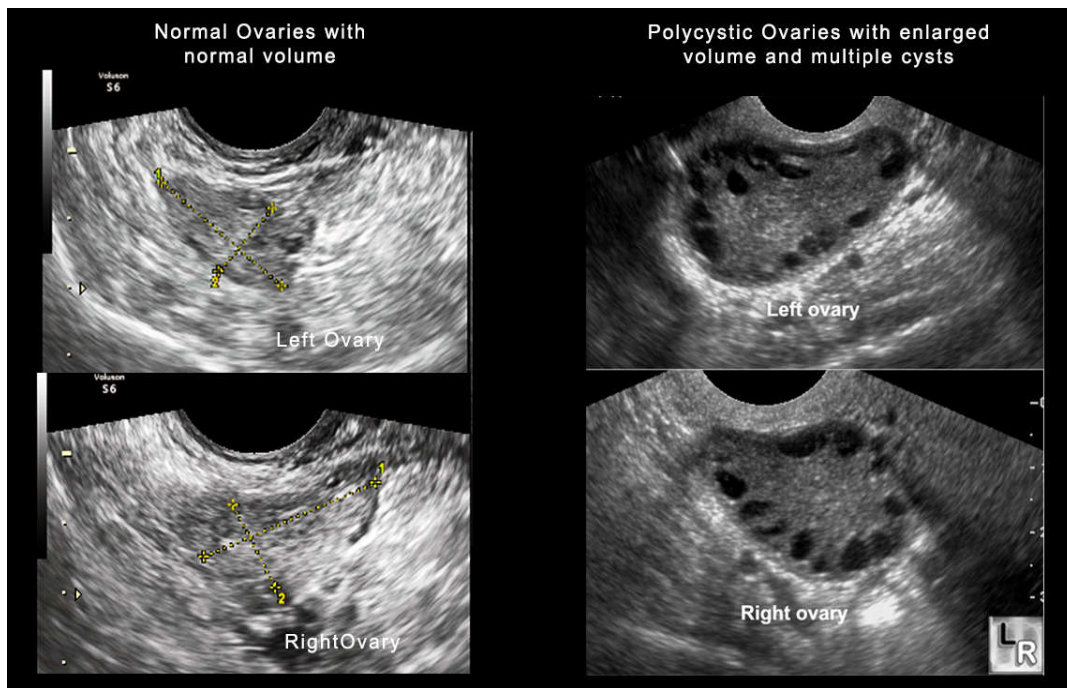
Ultrasound examination of PCOD
